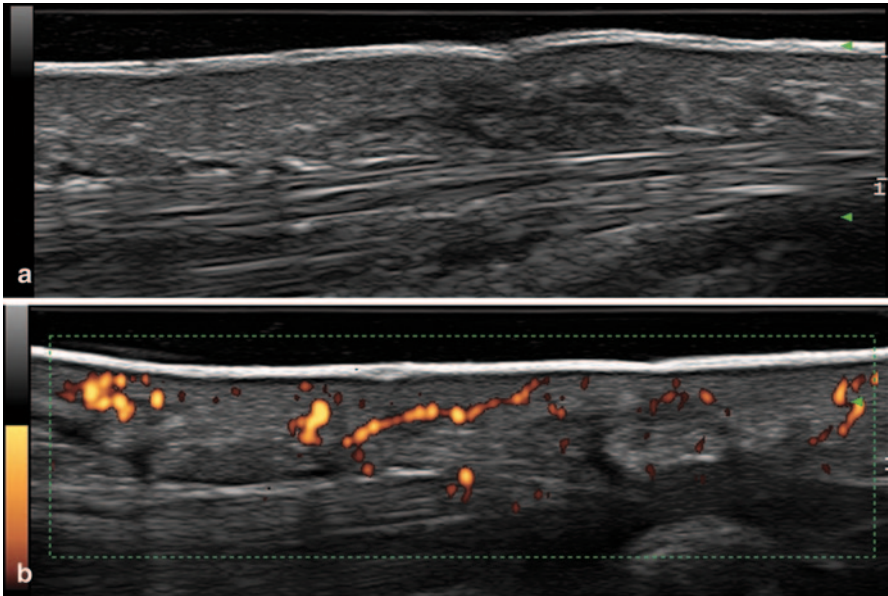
(a) Palmar fascia with hypoechoic nodular thickening. (b) Positive power Doppler signal
